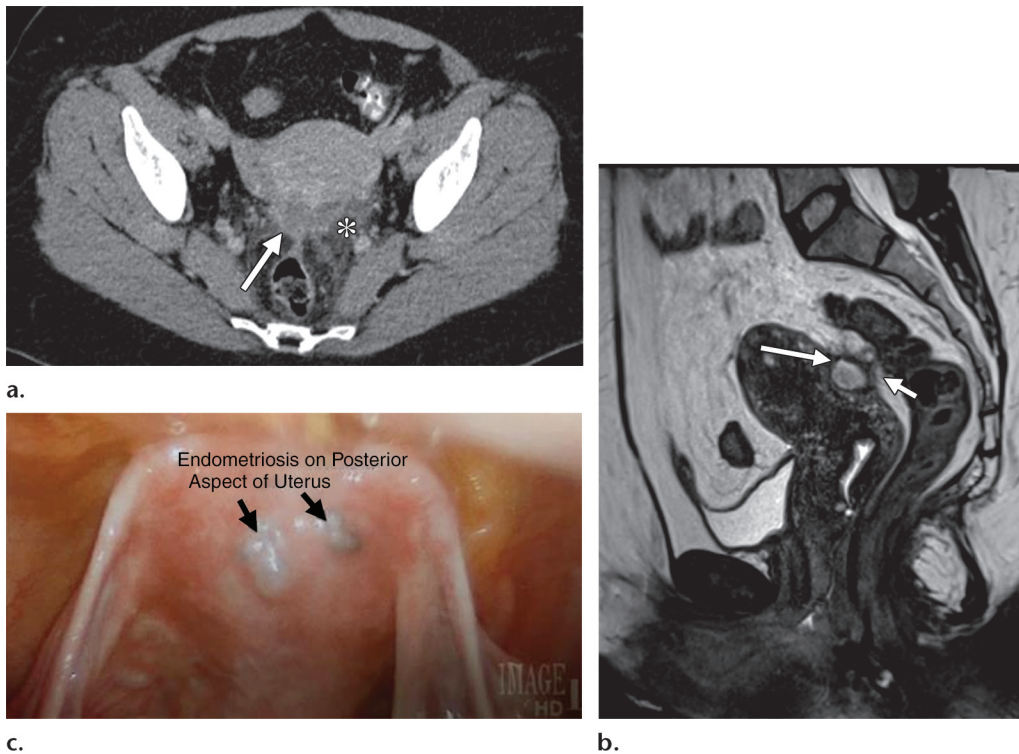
Endometriosis in a 32-year-old woman with pelvic pain and dyspareunia. (a) Axial contrast-enhanced CT image shows abnormal increased attenuation in the cul-de-sac (arrow), with surrounding inflammatory stranding (*). (b) Sagittal T2-weighted MR image shows a T2-hyperintense focus (long arrow) coating the posterior uterine surface, with tethering of the adjacent sigmoid colon (short arrow), findings consistent with endometriosis. (c) Intraoperative photograph shows the presence of endometrial implants (arrows).
